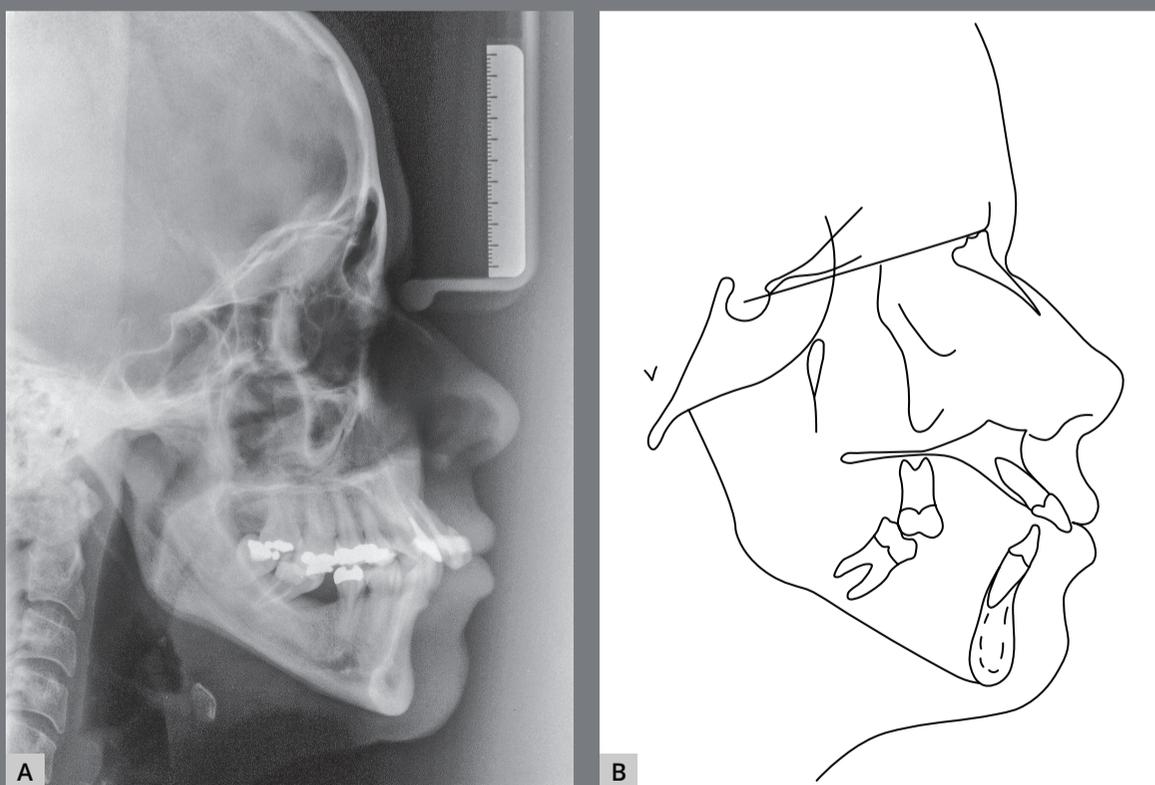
Initial cephalometric radiograph (A) and (B) cephalometric tracing.
